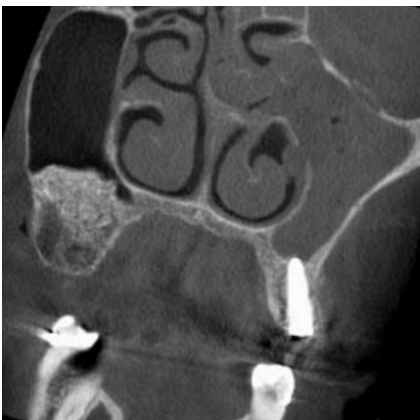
Coronal CBCT image, first molar region on the right, first premolar implant region on the left
